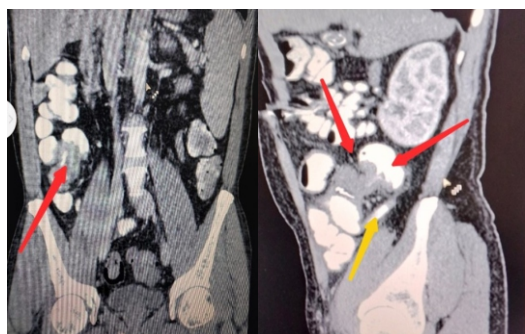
CT scan-Red arrow shows the ascending colon mass demonstrating filling defect (apple core deformity)
